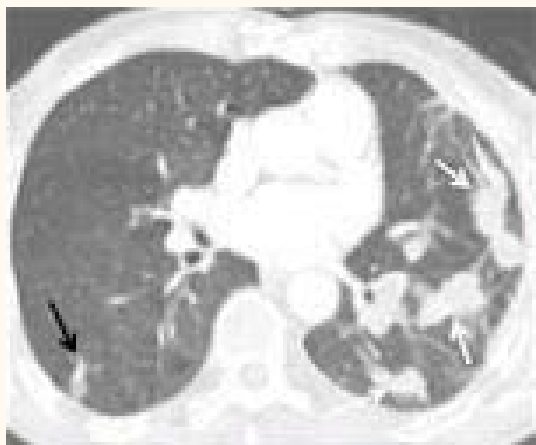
Multidetector computed tomography scan showing irregular, defined patchy lesions (black arrow in right, white arrows in left) in bilateral lung parenchyma, especially in the left on lung window.
